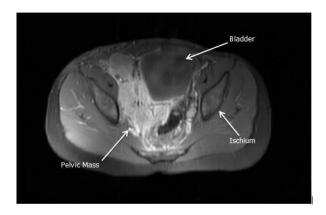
Axial, post contrast MRI image demonstrating enhancing pelvic mass.
